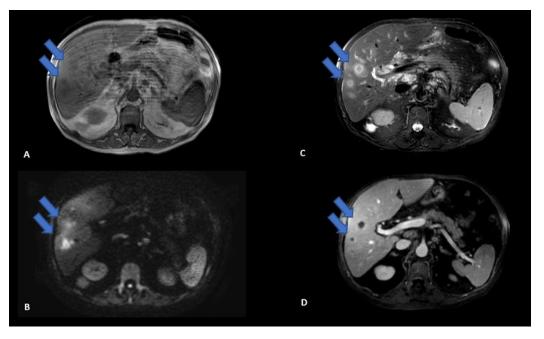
Magnetic resonance imaging sequences in T1 (A), T2 (B), DWI (C), and T1 post-gadolinium MRI in portal phase (D) revealed solid hepatic nodules (blue arrows), with mildly low signal on T1, predominantly high signal on peripheral T2, water diffusion restriction demonstrated on the diffusion-weighted sequence and confirmed on apparent diffusion coefficient map (not shown), and faint peripheral enhancement by the paramagnetic contrast agent.
